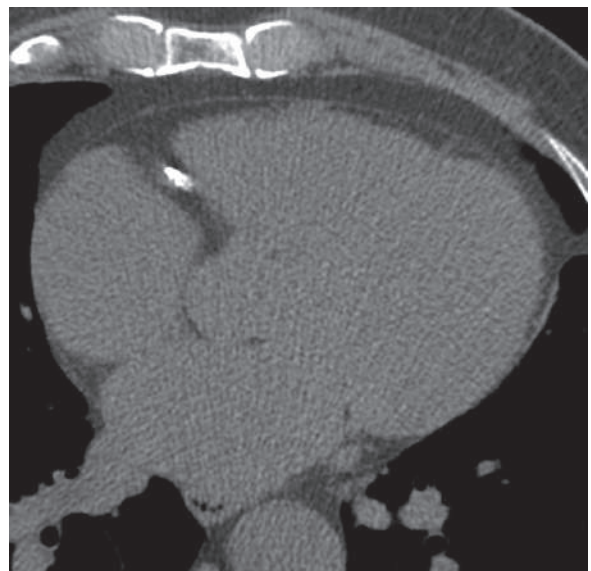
Axial non-enhanced cardiac CT examination for calcium scoring shows calcified plaque in the right coronary artery
